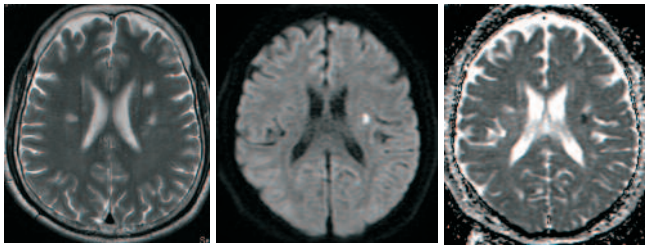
(a) T2WI Axial (b) DWI Axial (c) ADC Map Axial
